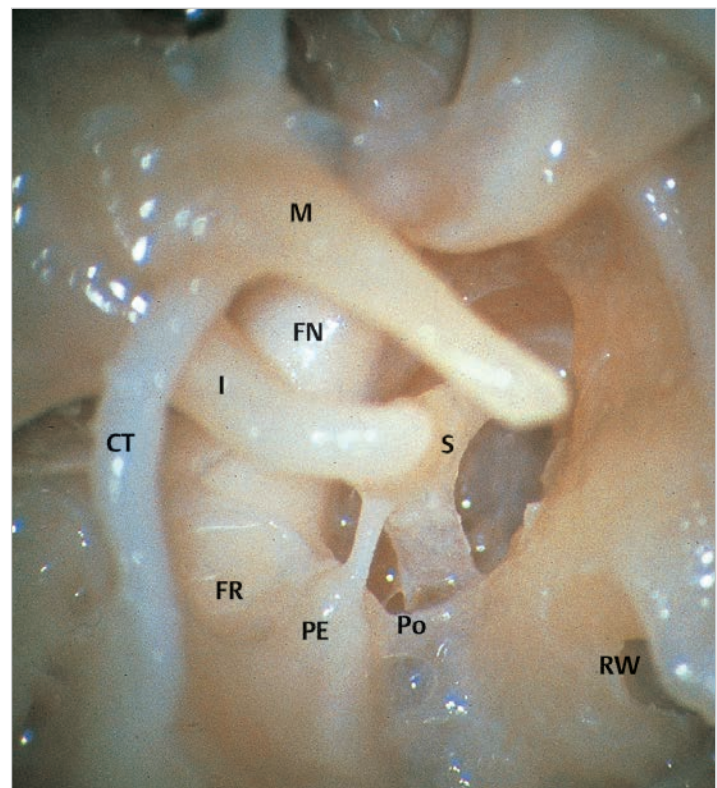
In higher magnification. CT, chorda tympani; FN, facial nerve; FR, facial recess; I, incus; M, malleus; PE, pyramidal eminence; Po: ponticulus; RW; round window niche; S, stapes; TS, tympanic sinus.
